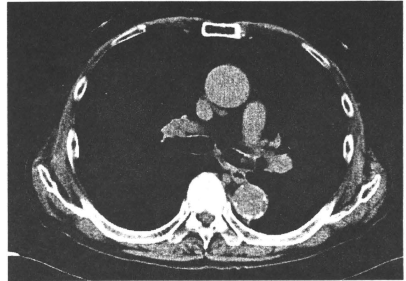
Computed tomography of the chest revealing a tumor in the left main bronchus.
